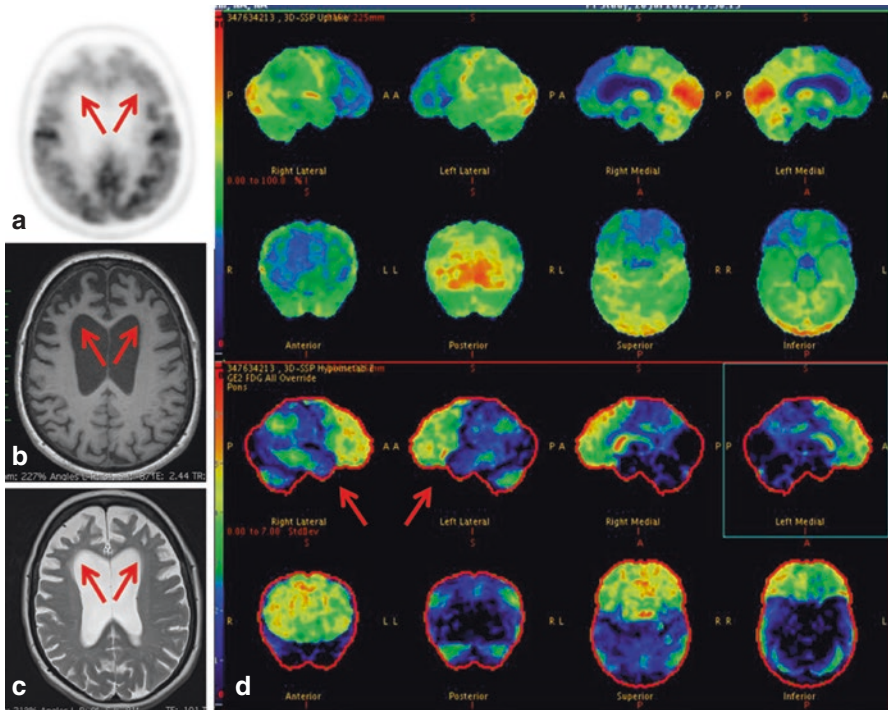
(a–d) Axial ^{18}F FDG PET (a), axial T1WI (b), axial T2WI (c) and Z-score maps (d) show reduced FDG uptake in the frontotemporal lobes bilaterally more pronounced in the frontal lobes (a, arrows) corresponding to cerebral atrophy on MRI (b, c arrows) and confirmed on quantification assessment (d, arrows), in keeping with frontotemporal dementia.
